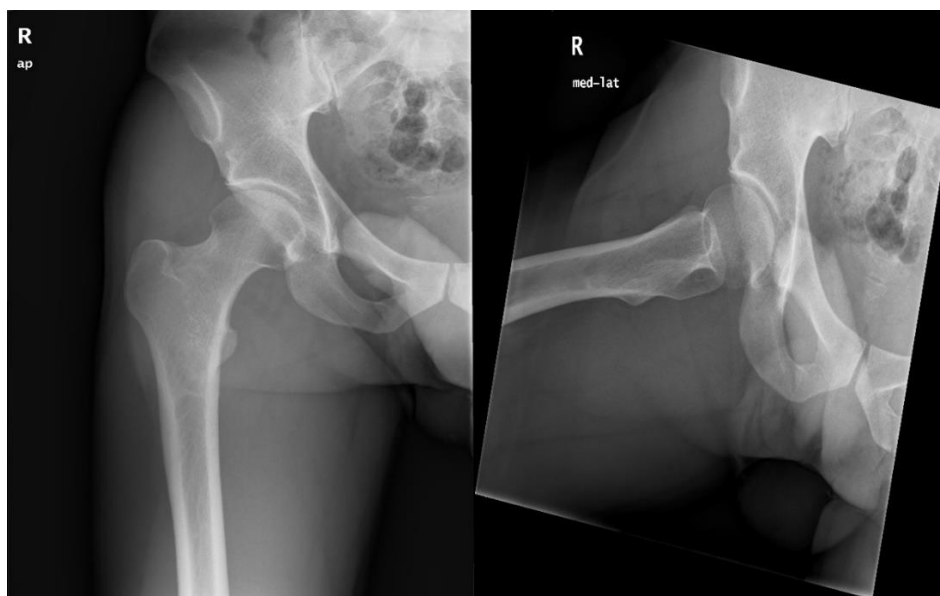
Hip X-ray of a 29-year-old male athlete, tennis player since adolescence. One notices the presence of an outgrowth of the acetabular labrum typical of the Pincer-type conflict.
